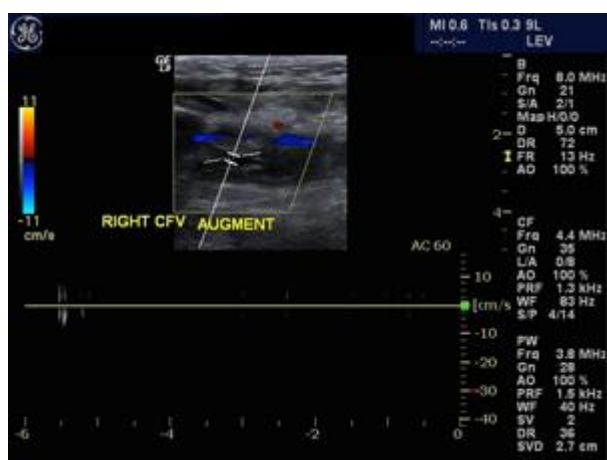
Color and Spectral Doppler image of the right common femoral vein.
